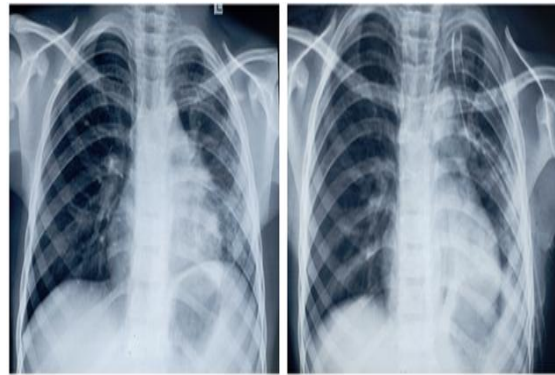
chest radiograph pre and post bronchoscopy for the third case with the foreign body in the left main bronchus and a chest tube in place following pneumothorax intraoperatively and the foreign body retrieve in the third picture
